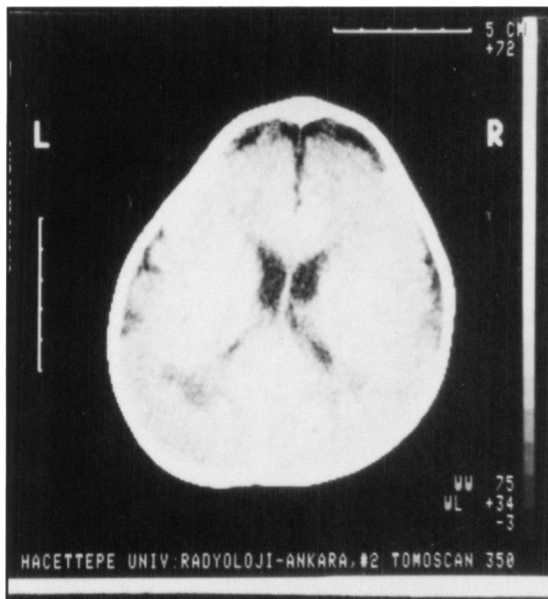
CT scan. Cortical atrophy, mild white matter hyperlucency around frontal and occipital ventricular horns.
